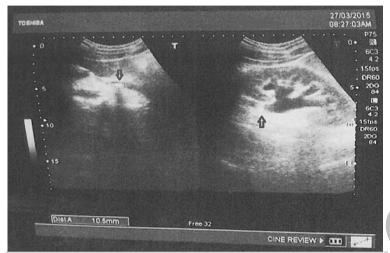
Renal ultrasound displaying the patient's left kidney: hydronephrosis due to stone in proximal part of the left ureter (arrowed).
